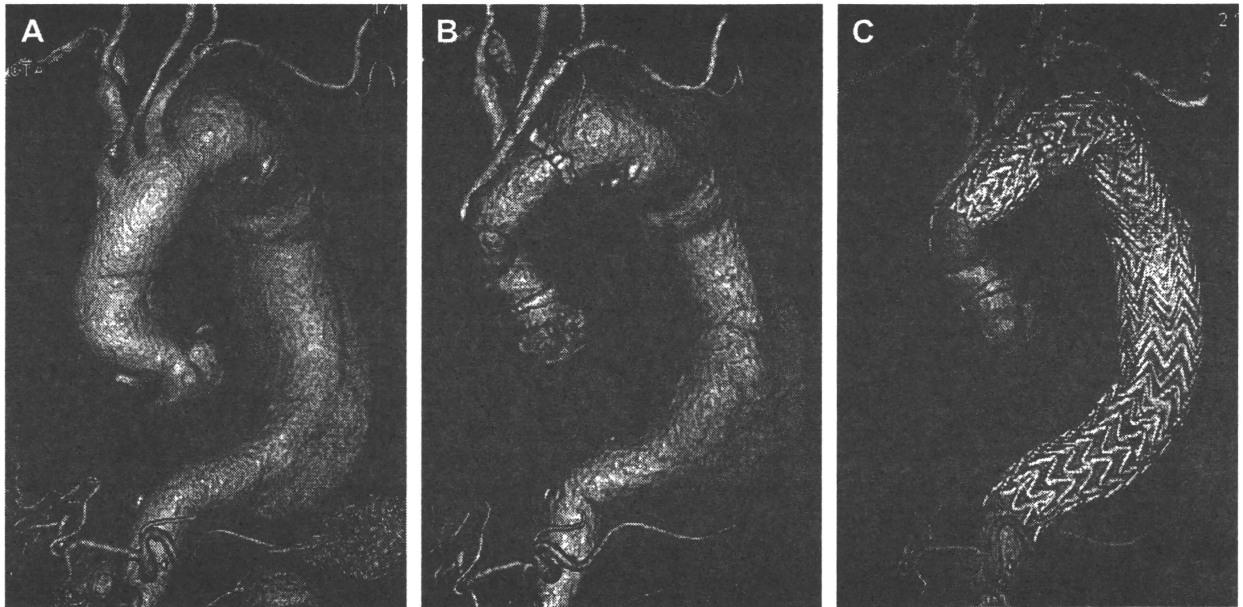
Sequence of CTA in Patient 2. Panel A: Preoperative, Panel B: After total arch replacement, Panel C: After TEVAR.
